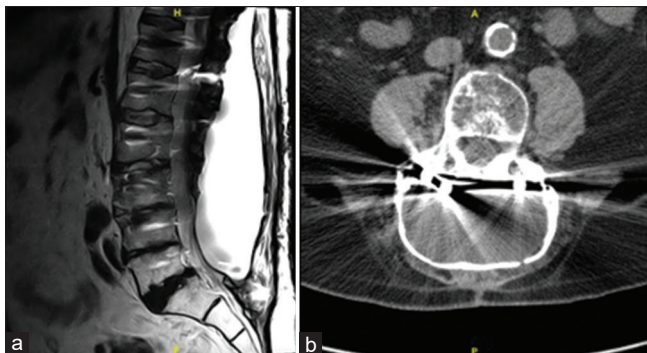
(a) T2-weighted magnetic resonance image. (b) Computed tomography without contrast at the L4 vertebral body. In largest dimension, the fluid collection was 8.2 × 5.2 × 25.3 cm.
